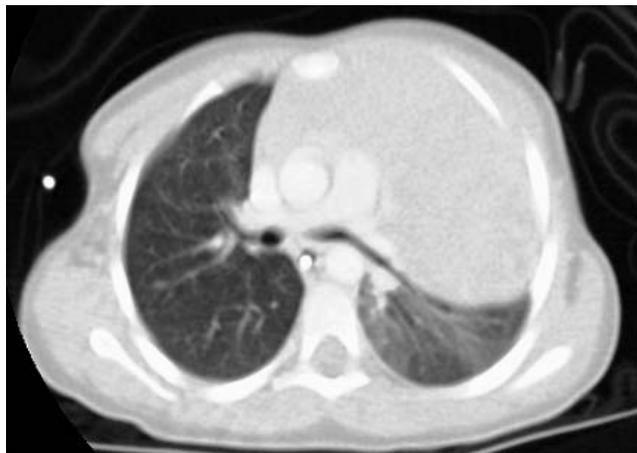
Computed tomography scan showing a bulky anterior mediastinal mass compressing the left bronchus of the patient described in case 3.
